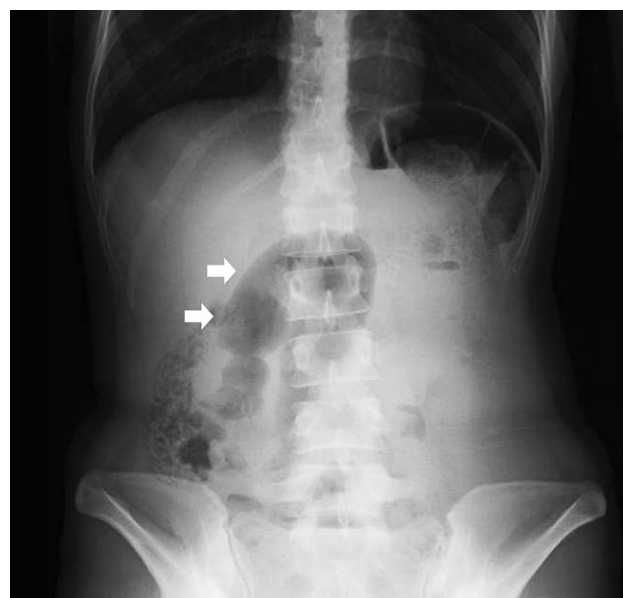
An abdominal X-ray reveals a sigmoid colon loop (white arrows) in the mid-abdomen.
